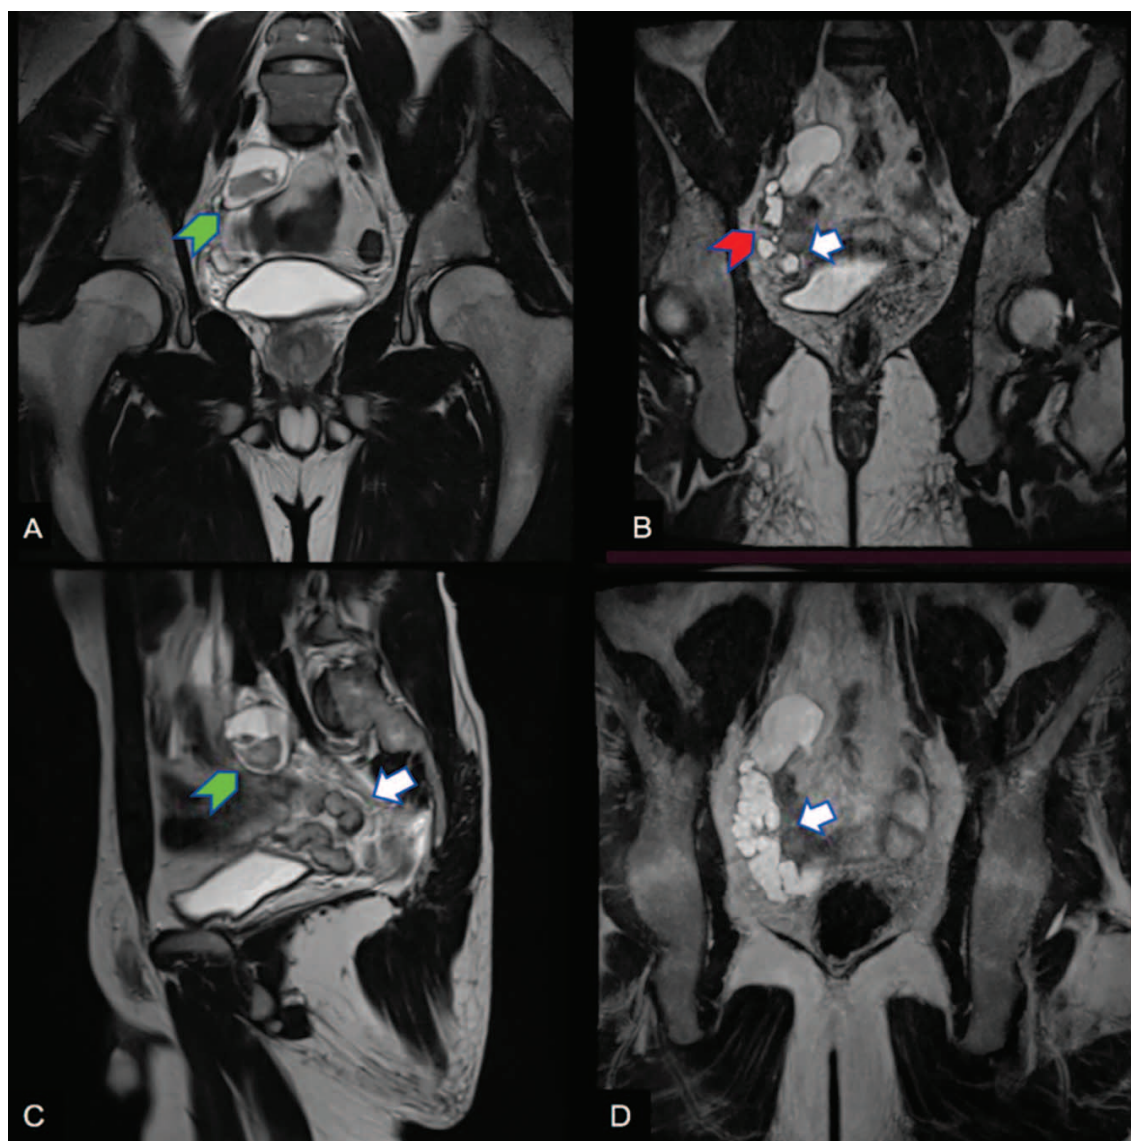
(A, B, D) Coronal T2 and T2 MIP MRI: cystic dilatation of tortuous seminal vesicles on the right (white arrow), in the form of T2 hypointense intraluminal changes with fluid levels (red arrow). An increase in the size of the seminal vesicle cyst on the right with a change in the intraluminal contents to heterogeneous on T2 with fluid level (green arrow), indicating possible differential diagnosis between purulent and hemorrhagic (C) Sagittal isotropic T2 MRI: cystic expansion of convoluted seminal vesicles on the right (white arrow), heterogeneous intraluminal contents in enlarged seminal vesicles on the right (green arrow)
